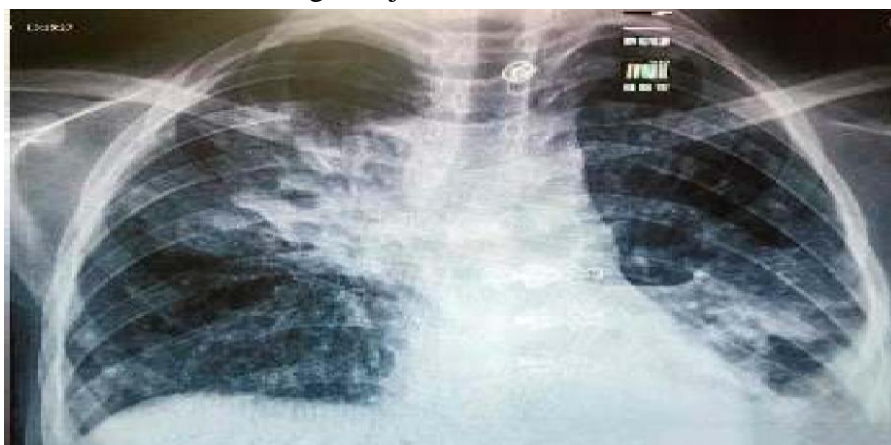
Chest x-ray showing extensive bilateral, ill-defined parenchymal opacities with bilateral pleural effusion
